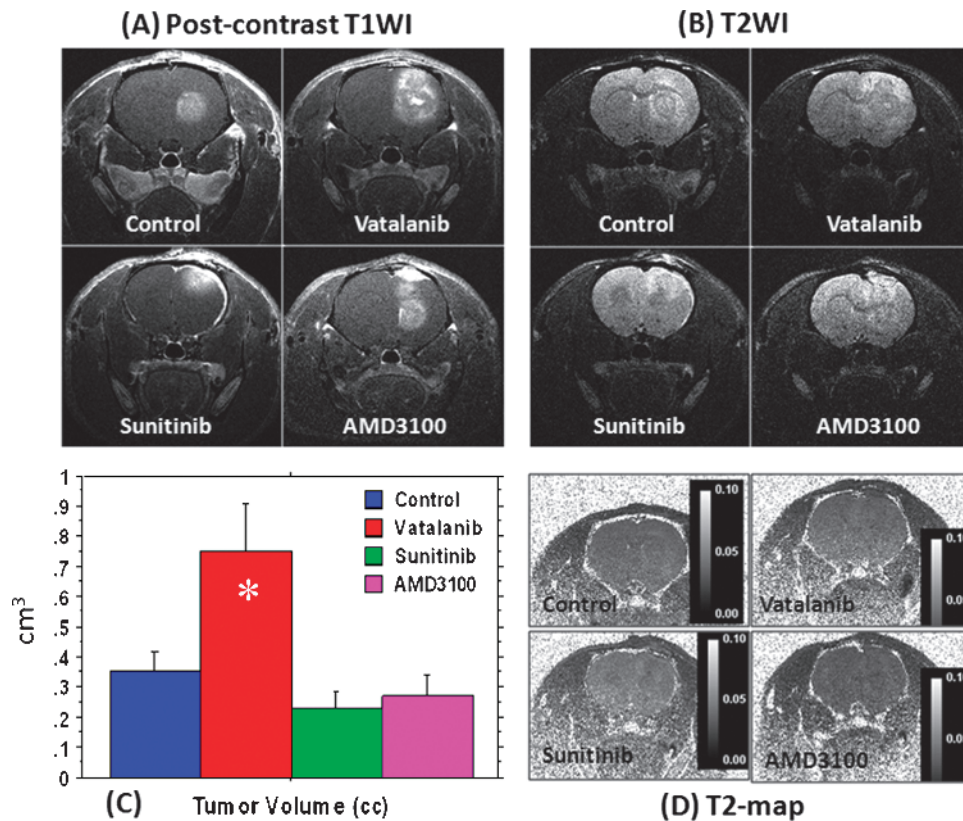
Effect of antiangiogenic treatment in U251 tumor determined by MRI. Postcontrast T1WI (A) and T2WI changes (B) after 2 weeks of antiangiogenic treatment with vatalanib, sunitinib, and AMD3100; tumor volumes measured after vehicle and drug treatment (C); T2 maps of U251 tumors following antiangiogenic therapy showed no significant edema or necrosis compared to the vehicle-treated tumor (D). * $P < .05$. All tumors were in the right hemisphere.
